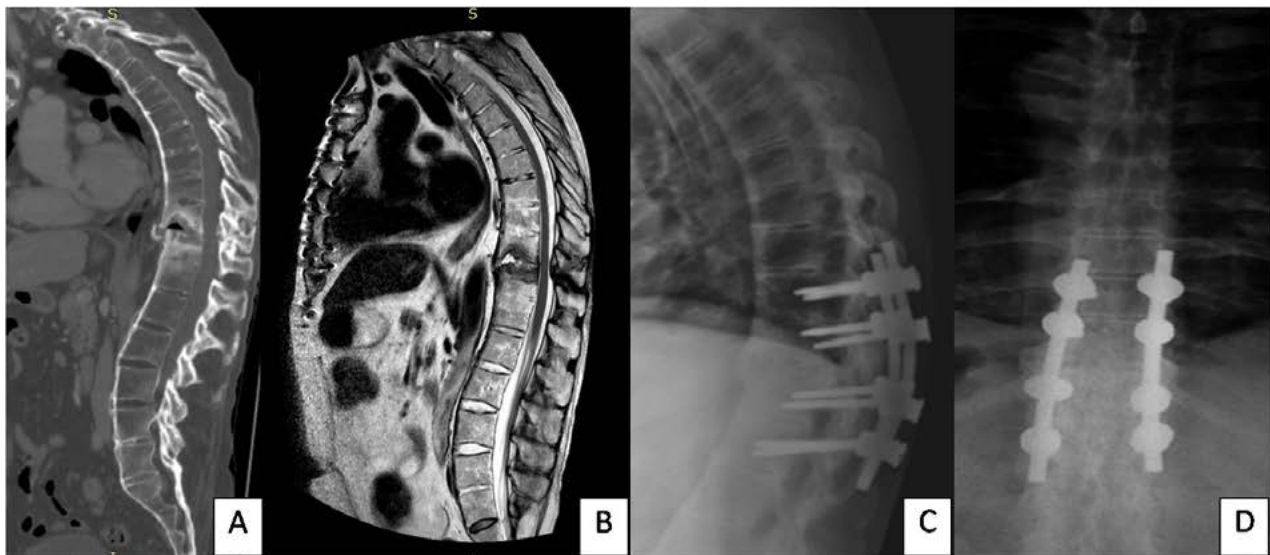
This 54 patient had a fall from the height 2 months before, developing chronic low back pain. Figure 2A - A sagittal T2 sequence thoracic spine MRI shows a T10 fracture with anterior vertebral elements distraction. Figure 2B - The CT scan documented the fracture and also gas inside the intervertebral disc. A T9-T10 pedicle screw fixation was performed with total pain relief (Figure 2C with the plain radiographs after surgery).
